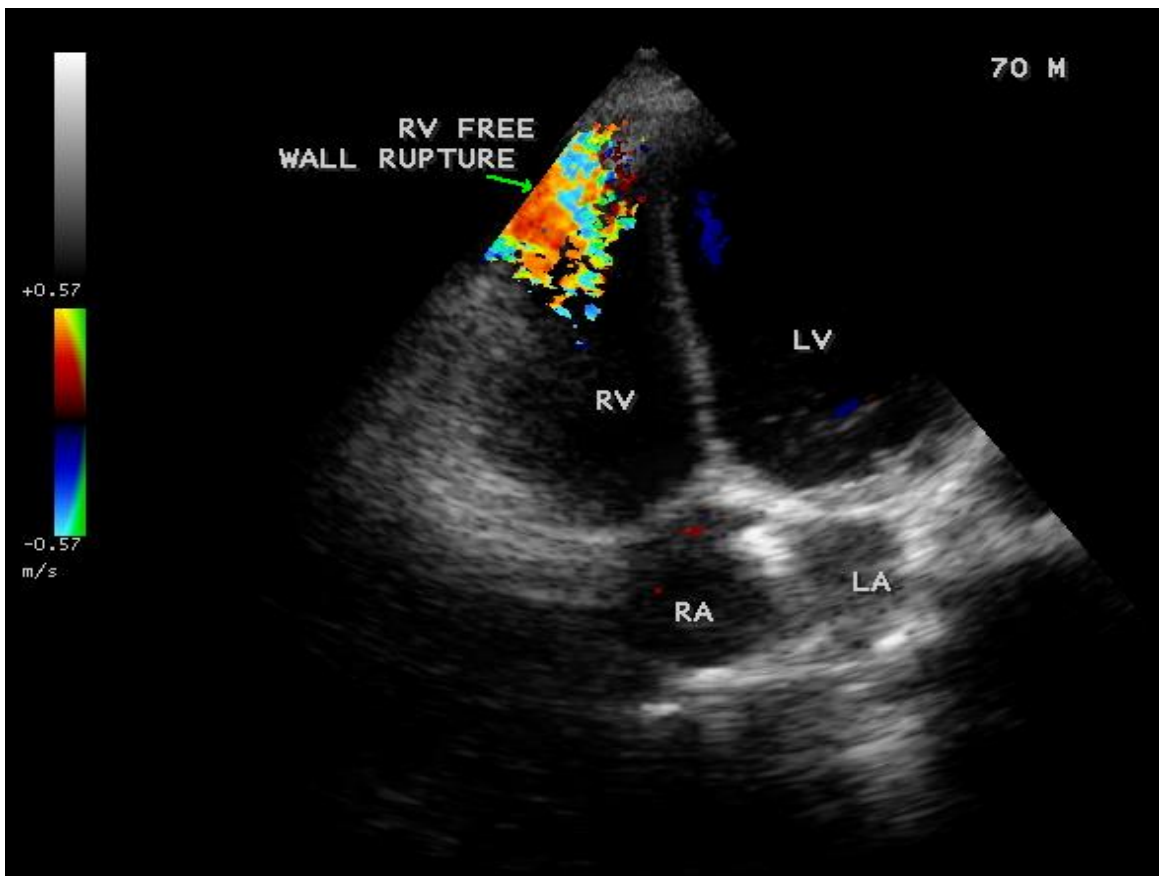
Color Doppler imaging showing the RV free wall rupture with a dense doppler signal in a 70-year old male with right ventricular infarction.
